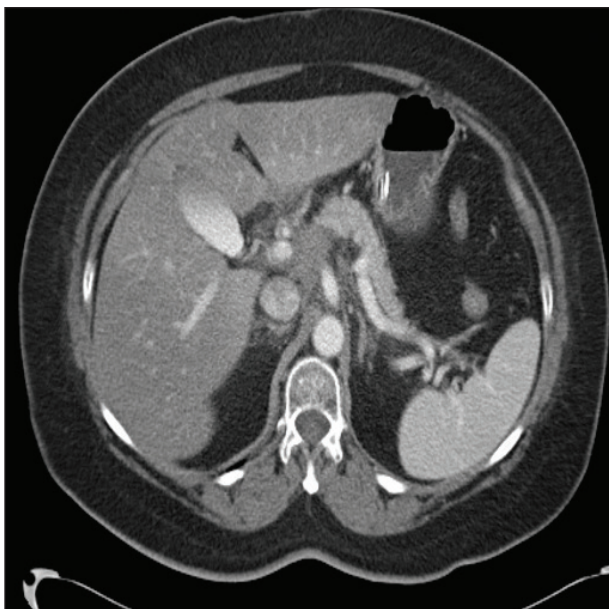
A CT scan taken 24 hours after IRE.
